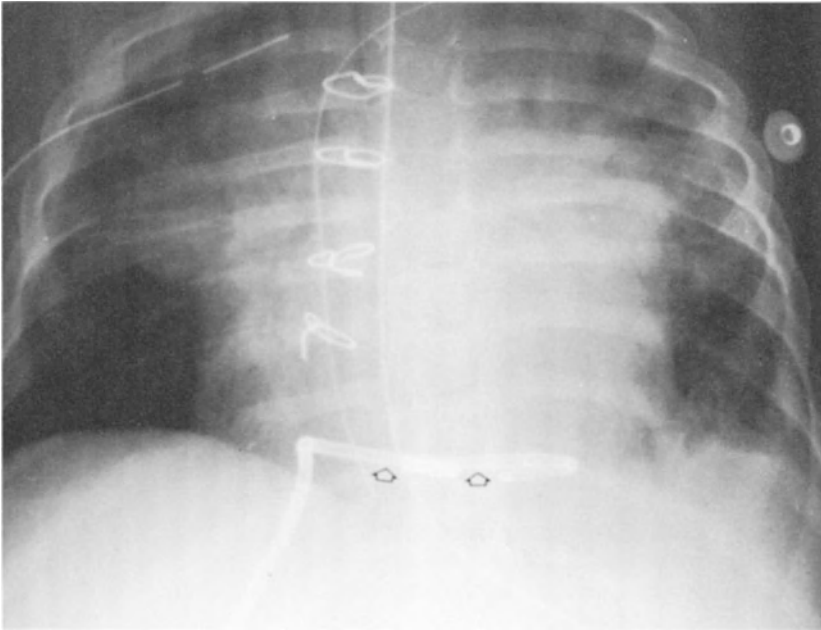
PA and lateral roentgenogram of a pericardial pigtail catheter. The catheter was directed inferiorly and posteriorly at the time of placement
